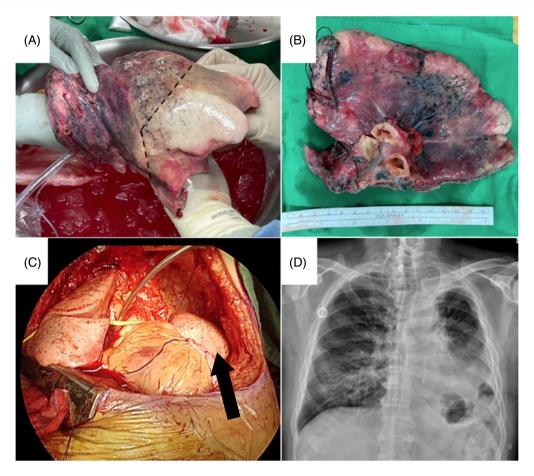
Images obtained during the operation. (A) Back-table sleeve resection. (B) Divided LUL lung (tumour part). (C) The arrow shows the full expansion graft. (D) Chest radiography findings at the follow-up 1 month after the operation.
